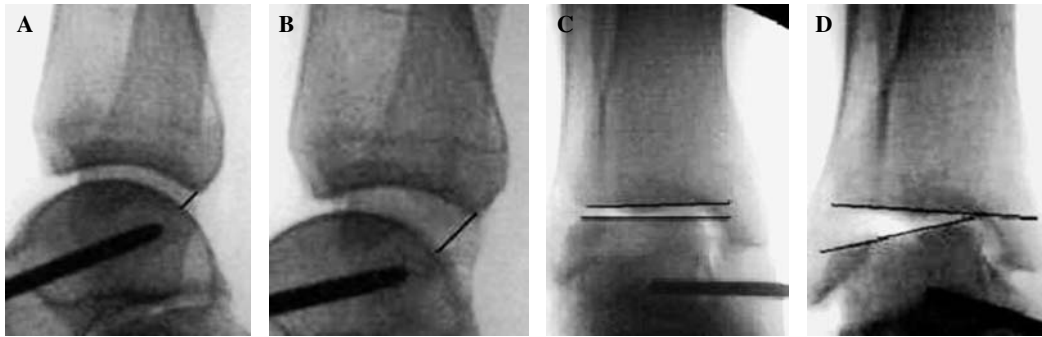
Radiographs showing the measurements made to calculate anterior drawer and talar tilt: unstressed anterior drawer (A), stressed anterior drawer (B), unstressed talar tilt (C), and stressed talar tilt (D).
